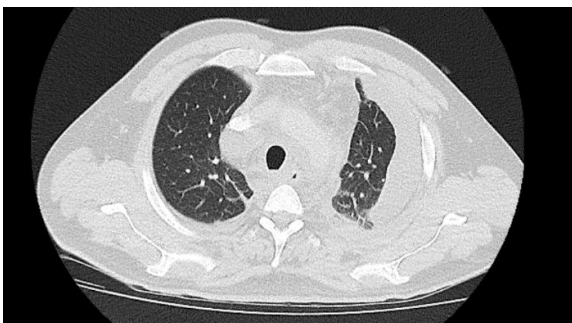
Computed tomography (CT) of the chest: left pleural effusion, as well as atelectasis located in the lower lobe of the left lung, right lung spared.
